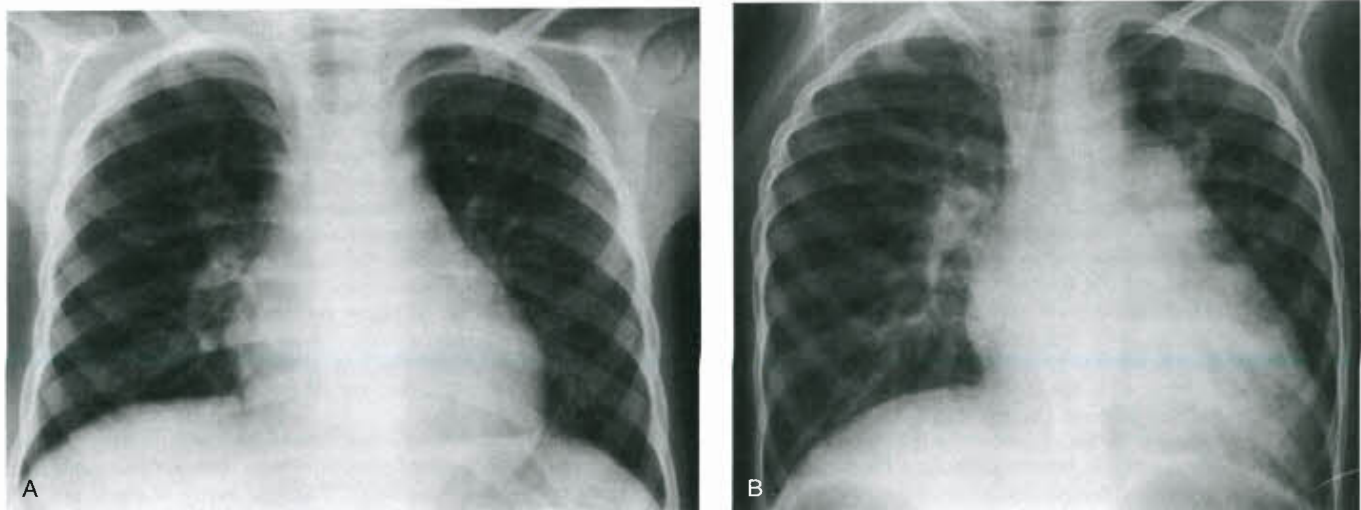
Posterior–anterior chest roentgenograms in two children each with a patent ductus arteriosus. A: A 4-year-old child with a small left-to-right shunt. Slight cardiomegaly and prominence of the pulmonary vasculature are present. B: A 4-year-old child with a very large left-to-right shunt. A double density and elevation of the left mainstem bronchus are present owing to LA enlargement. The LV, main and peripheral pulmonary arteries, and ascending aorta are prominent. Pulmonary venous congestion is also present.
